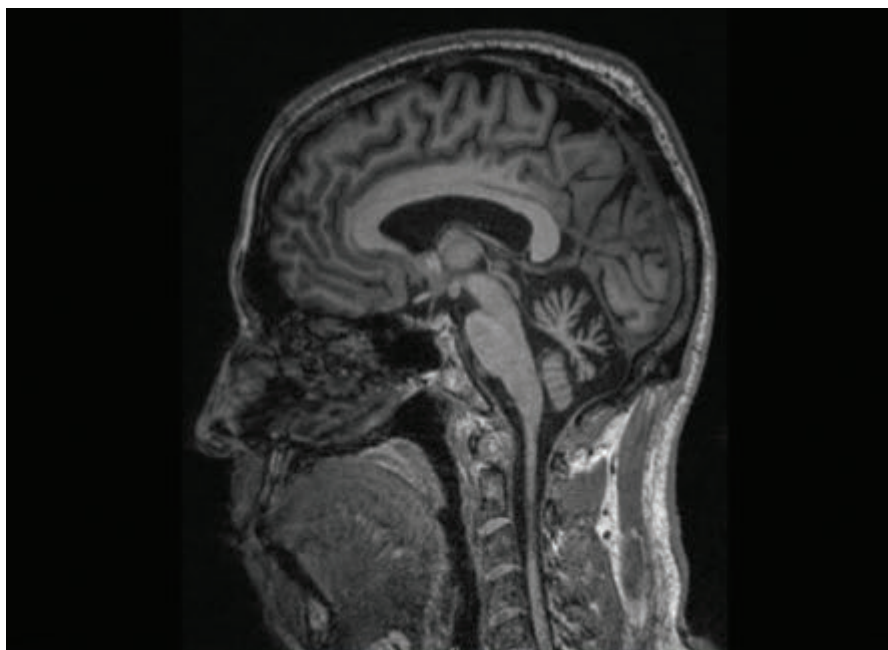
Sagittal T1 weighted MRI (40 year-old man with variant ataxia telangiectasia), showing cerebellar atrophy.
